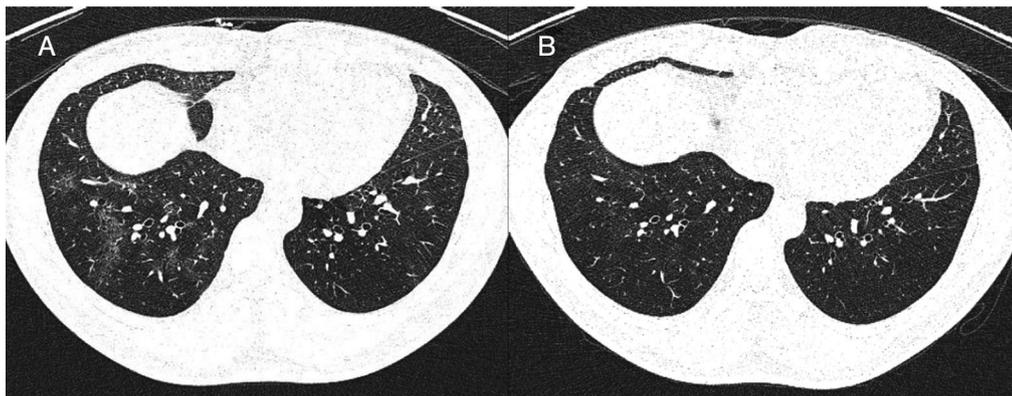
CT findings during a follow up for lung injury due to HDs inhalation. (A) Computed tomography, 6 years ago. Multiple focal GGOs with bubble-like lucency and air cyst in both lungs. Small nodules in the subpleural area of the right middle lobe and along the right major fissure Paraseptal emphysemas in the left upper lobe posterior segment; (B) Computed tomography, 3 years ago. Decreased extent of peribronchial multifocal patch GGOs in both lungs. Decrease in extent of focal reticulation. No change in the paraseptal emphysema in the LUL and small nodules in both lungs. CT = computed tomography; HD = humidifier disinfectant; GGO = ground-glass opacity.
